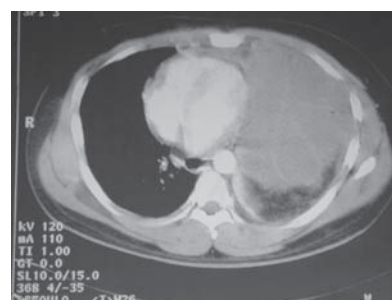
Thoracic computed tomography identified the collection of fluids in the left lower thorax in combination with soft tissue component. A consolidated pneumonia and empyema were considered as potential differential diagnoses.
